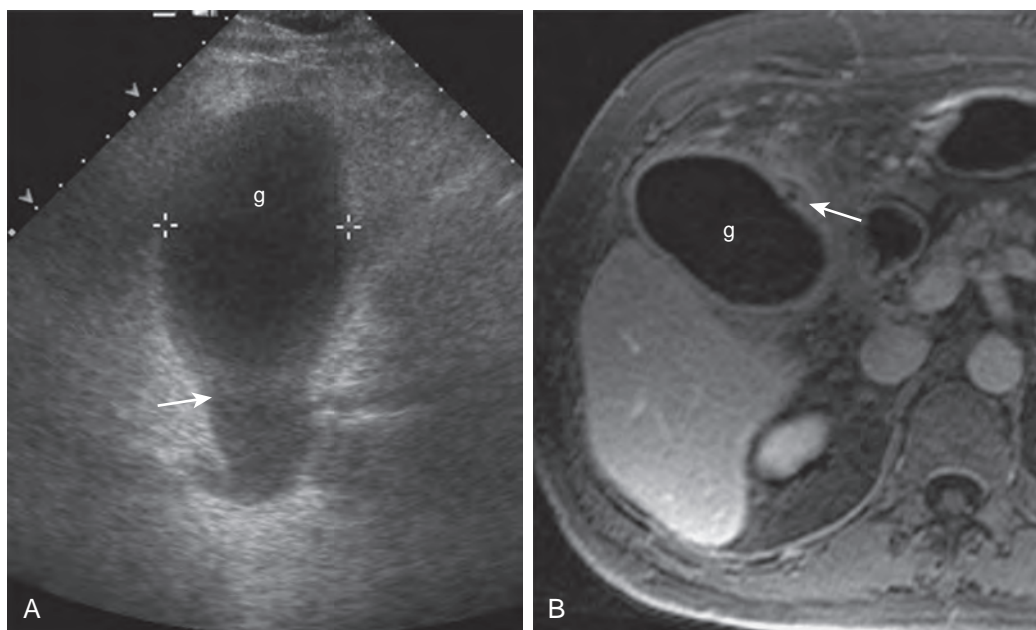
Acute acalculous cholecystitis: ultrasound and MR features. A. Ultrasound demonstrates markedly distended gallbladder (g) with layering sludge (arrow). B. Axial T1-weighted fat-suppressed gradient-echo image with gadolinium enhancement demonstrates distended gallbladder (g), wall thickening, and pericholecystic inflammatory change. Arrow points to small intramural abscess not suspected clinically.
